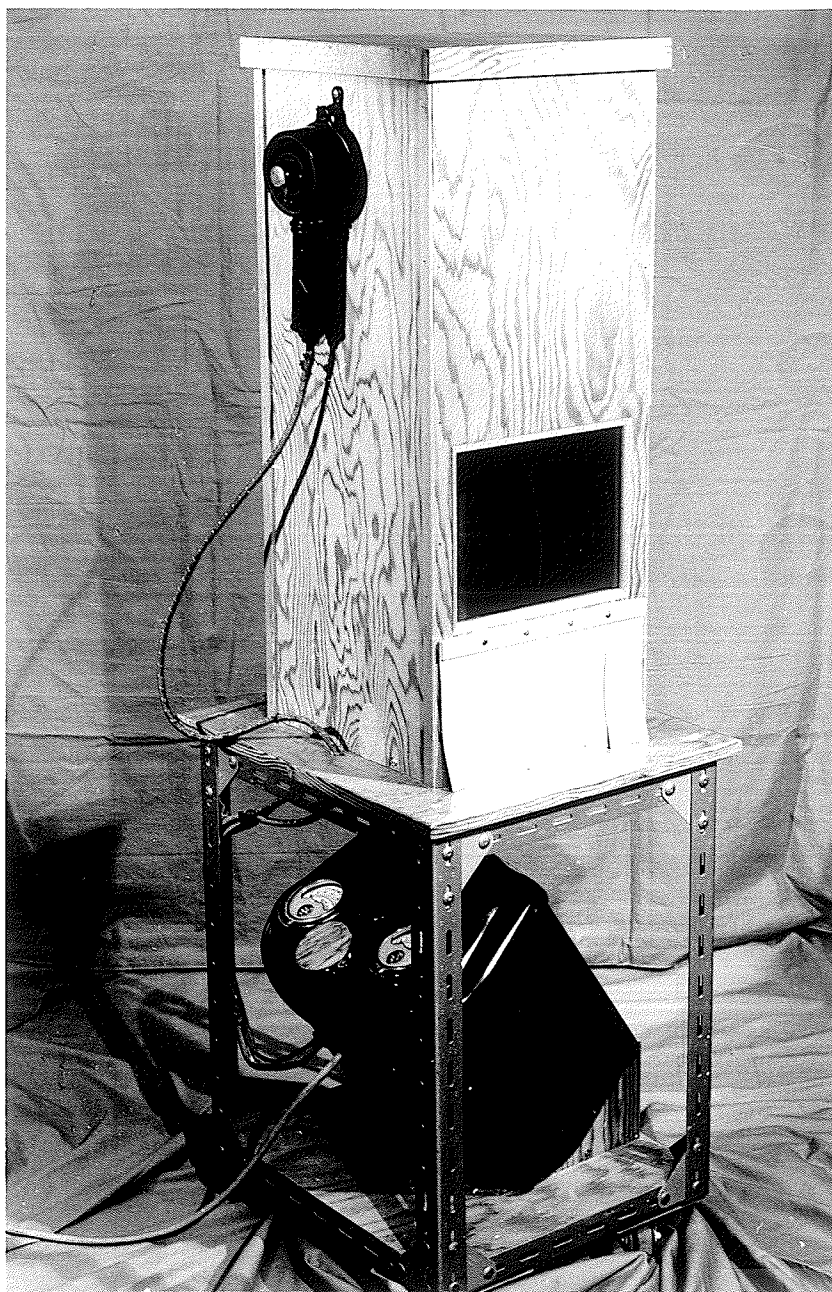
Portable hand-wrist x-ray machine (Nevile, 1973).
